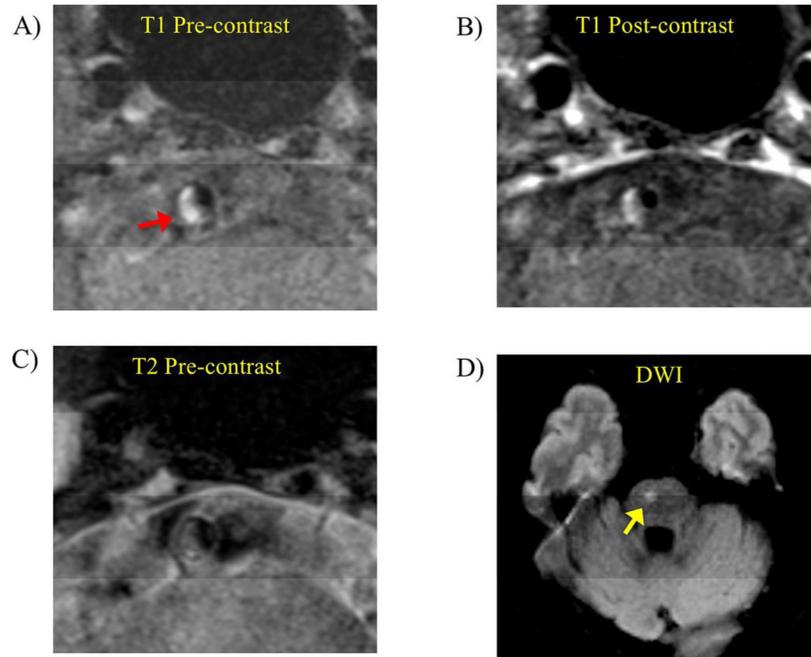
Intraplaque hemorrhage presented in a low grade stenotic basilar artery plaque (43% degree of stenosis) in an acute symptomatic patient (age 65, female). A) T1 weighted black blood MRI showed high signal (fresh IPH, red arrow) in the plaque. B) Post contrast T1 weighted images showed slight enhancement of the plaque. C) T2 weighted images showed iso-intense signal of the plaque. D) DWI showed infarct in the brain stem (yellow arrow).
